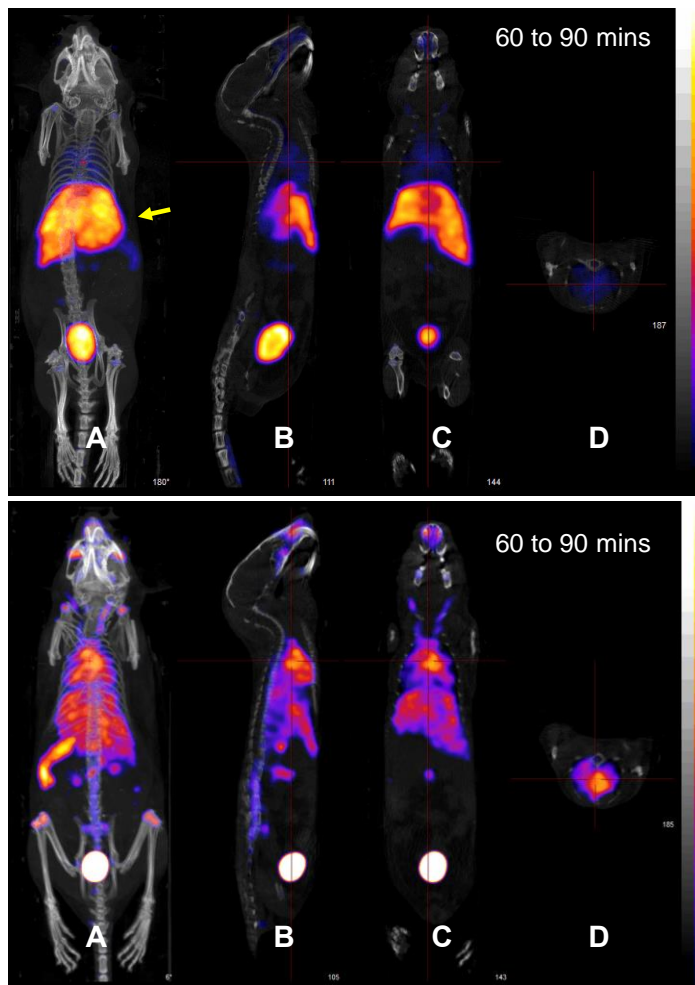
Single-photon emission computed tomography (SPECT) images of radiolabelled particles showing bio-distribution with or without treatment to block RES uptake. Top panel, (untreated) SPIONs taken up by liver (yellow arrow). Bottom panel, (Treated) SPIONs remain longer in circulation.
